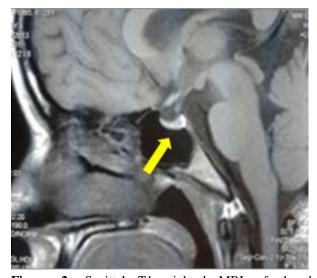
Sagittal T1-weighted MRI of the brain demonstrating regression of the pituitary mass after six months of thyroid hormone replacement therapy.
